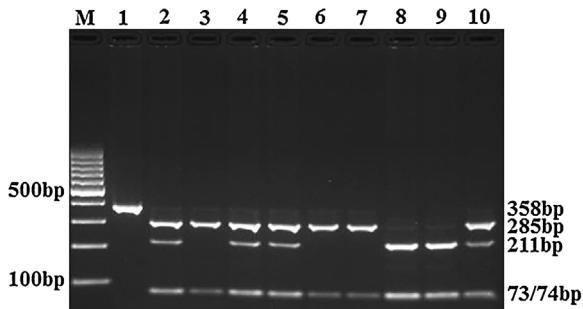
PCR-RFLP analysis of +1332C/T polymorphism of the GAS6 gene. The 3 patterns represent the C- and T-containing genotypes, namely, the homozygous CC and TT forms and the heterozygous CT form. Lane M shows the size markers, and lane 1, undigested PCR product; Lanes 8 and 9 show the CC genotype; 2, 4, 5 and 10, the CT genotype; and 3, 6 and 7, the TT genotype.
